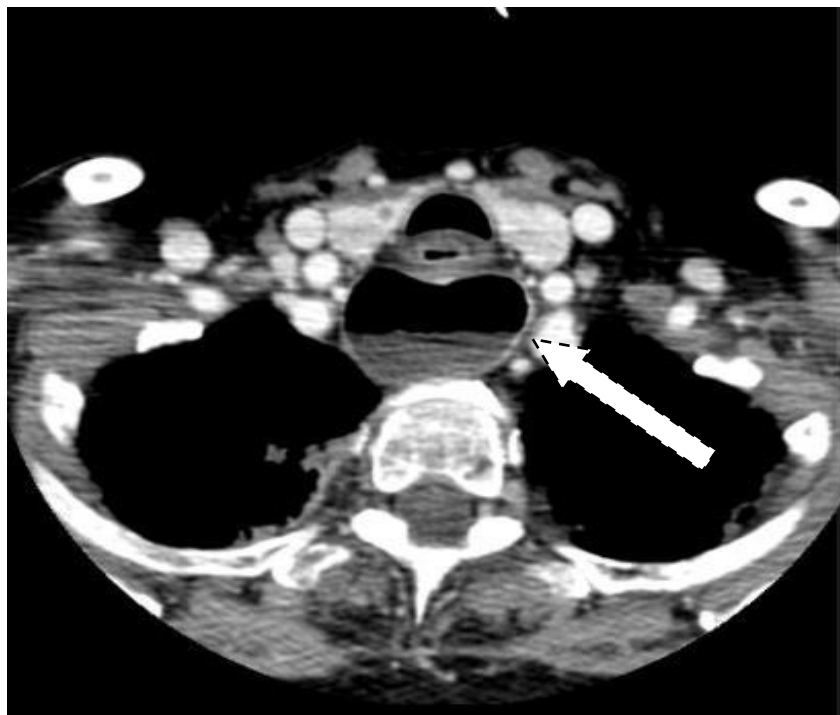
Cervico-thoracic CT scan showing a 3.5 cm cervical retrooesophageal mixed content formation suggestive of Zenker's diverticulum on axial section
